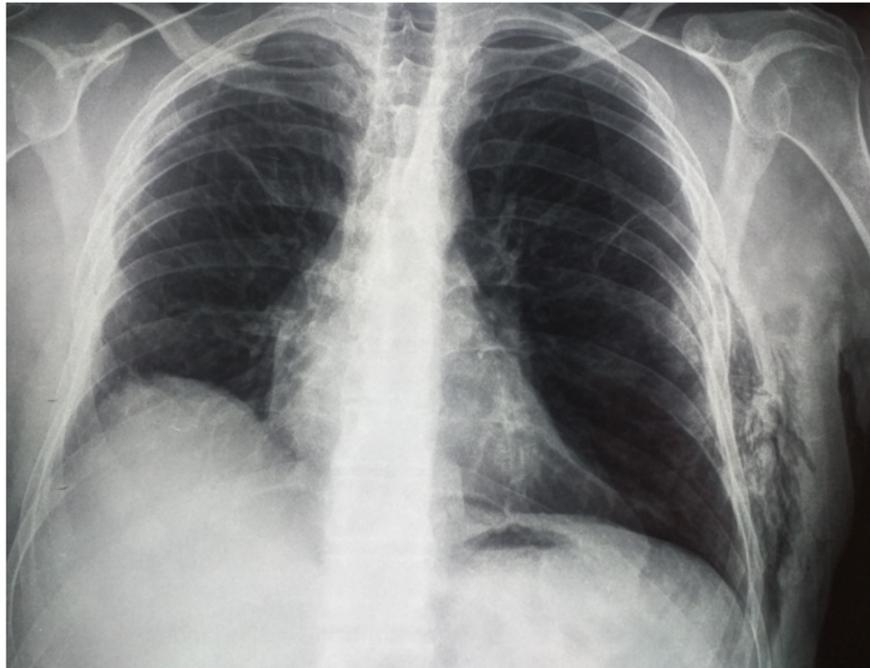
Chest X-ray: parietal air image.
